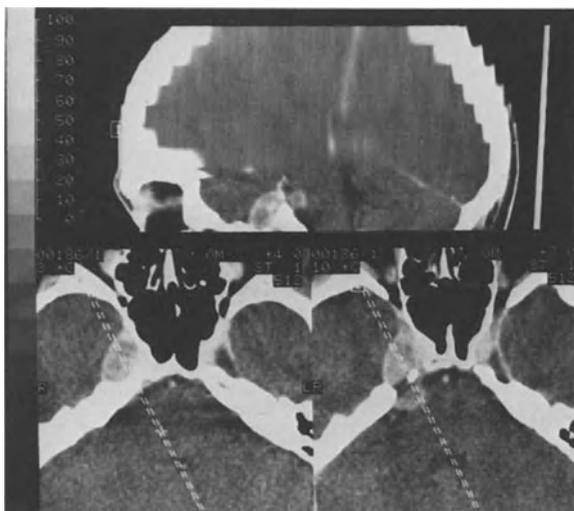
Preoperative CT scan of case No. 3 (Table 2)
